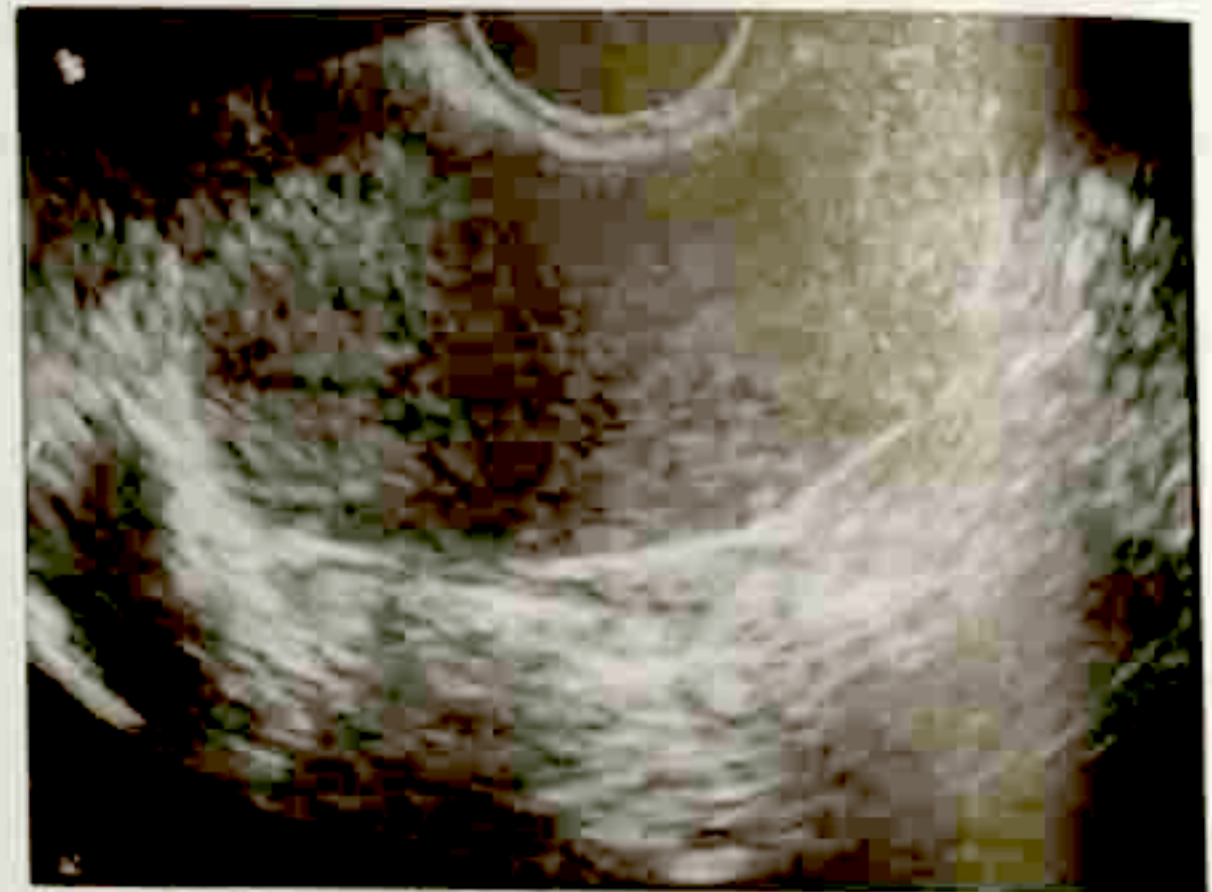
Transvaginal ultrasound showing widened transverse diameter.
